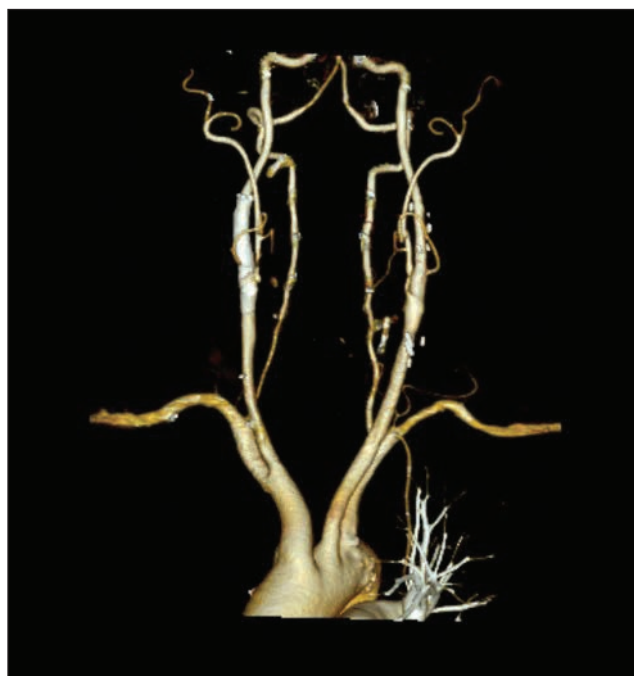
CTA at 6-month follow-up showed a widely patent stent without kinks or deficits.
